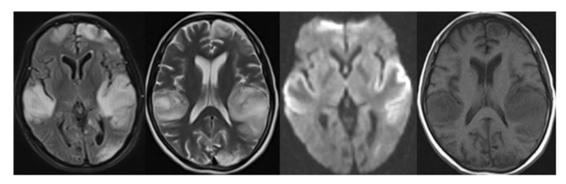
First brain MRI showed hyper-intense areas in left frontal and occipital lobes, the possibility of juvenile CVA considered due to restriction pattern.
